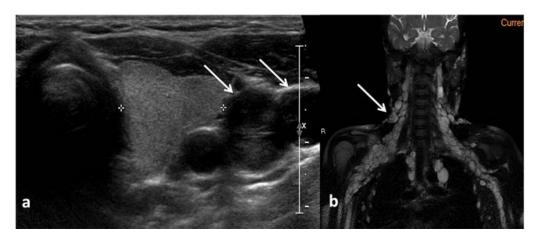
Thyroid ultrasound of a 15-year-old female with neurofibromatosis type I (NF-1) (a) demonstrating multiple lobulated hypoechoic solid lesions posterolateral to the left thyroid lobe (arrows). Coronal STIR MRI neck (b) shows innumerable fusiform lesions (arrow) from the skull base to both sides of the neck and axillae along the brachial plexus in keeping with plexiform neurofibromatosis. Neurofibromas typically demonstrate 'target sign' with central area of hypointensity and peripheral hyperintense rim.
